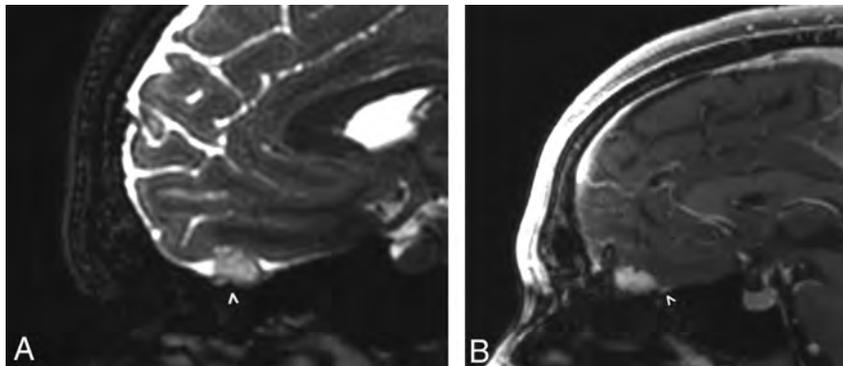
A 27-year-old man with mild hyperprolactinemia (case 1). Sagittal FIESTA (A) demonstrates a T2 hyperintense apparent extra-axial mass (arrowhead) within the left anterior cranial fossa. On the sagittal postcontrast T1-weighted image (B), the mass has uniform enhancement with a subtle adjacent dural tail (arrowhead). On imaging, this was believed to be a meningioma, but at resection, it was determined to be a pilocytic astrocytoma.
